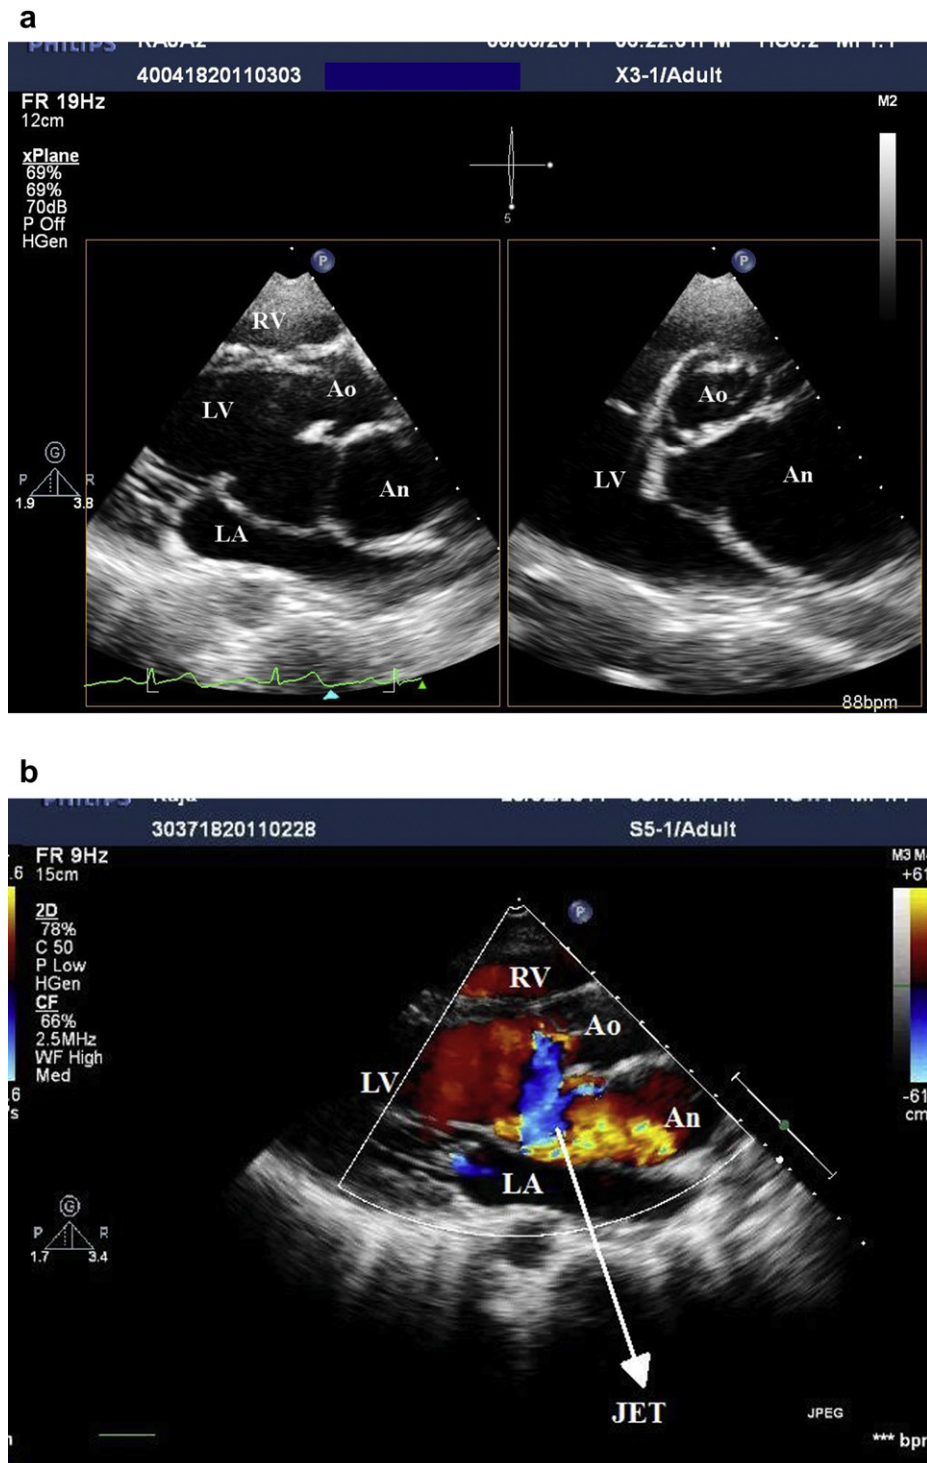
a Transthoracic echocardiography with parasternal long axis view and parasternal short axis view at aortic valve level showing large pseudo-aneurysm in the region of mitral-aortic intervalvular fibrosa. LV = Left ventricle, Ao = Aorta, An = Aneurysm, LA = Left atrium, RV = Right ventricle. b Color doppler imaging showing to and fro movement of blood between pseudo-aneurysm and left ventricle. There is no communication of pseudo-aneurysm with left atrium or aorta.
